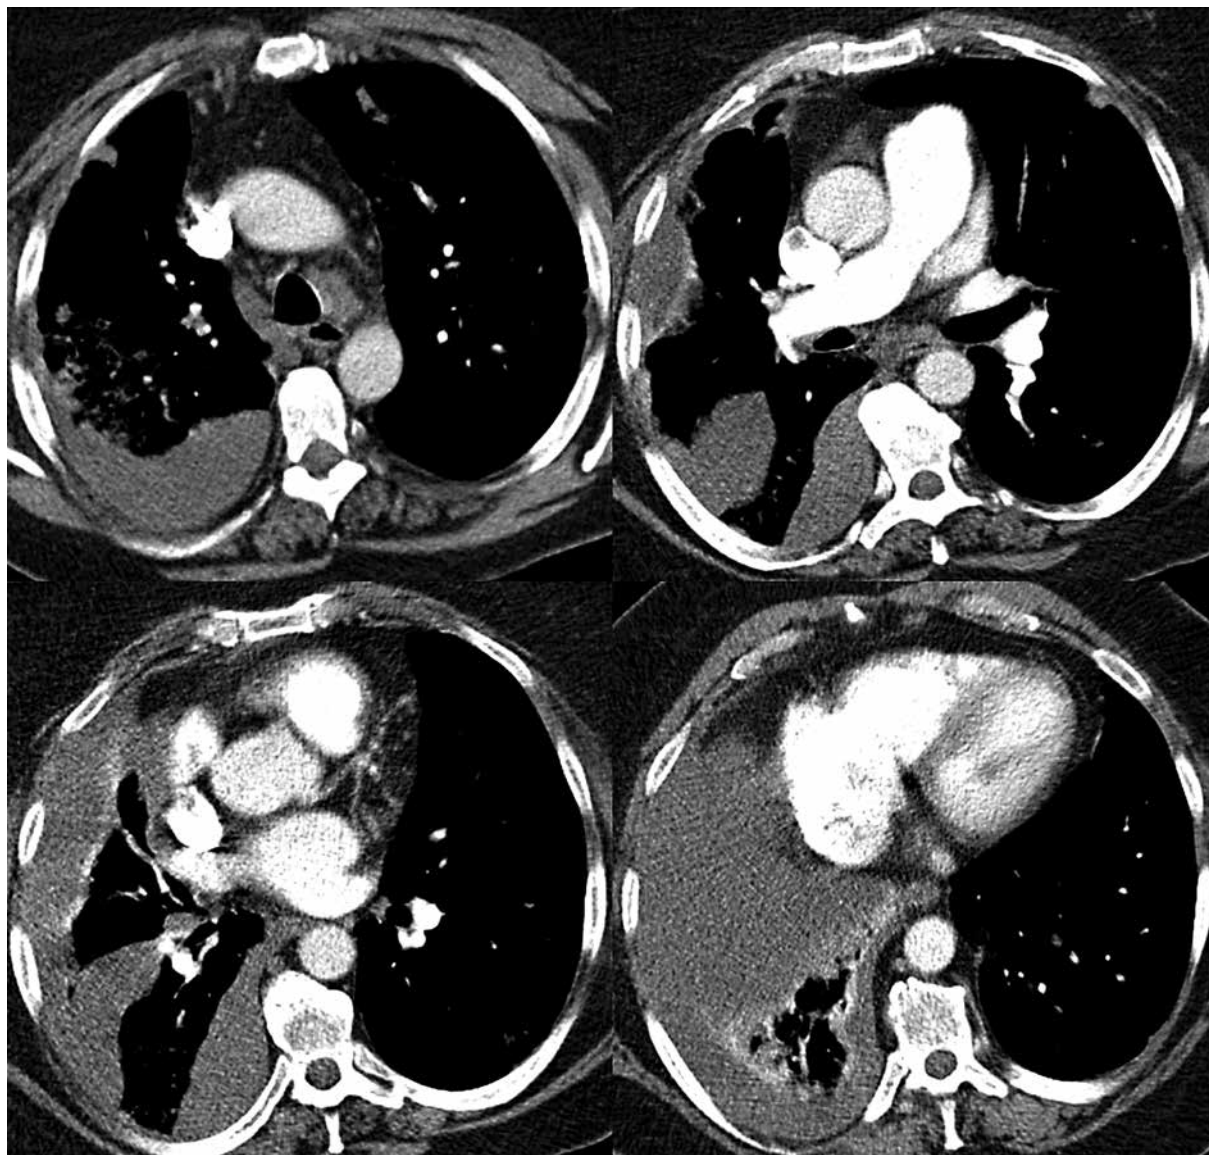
Computed tomography scan shows a large right pleural effusion
